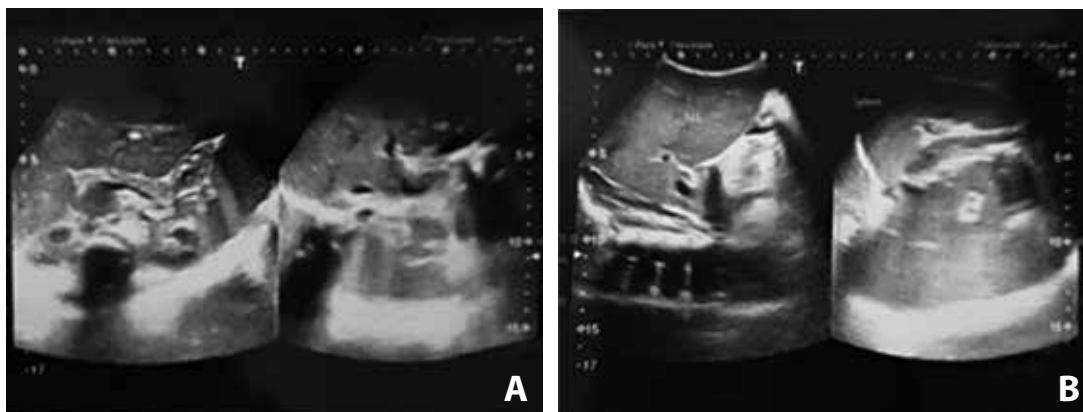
Abdomen Ultrasound examination showed liver enlargement.
